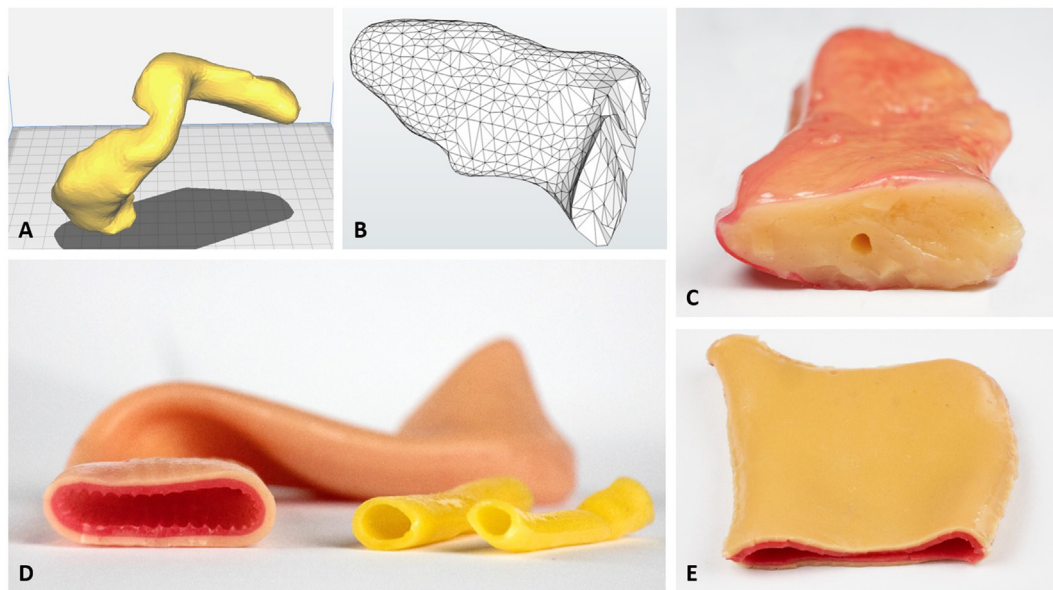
Silicone organ models. A: Pancreas 3D reconstruction of CT imaging. B: Final 3D pancreas model after virtual pancreatic head resection. C: Soft pancreas model with 3 mm duct. D: Small bowel with 2.5 mm wall thickness and soft bile ducts with 6 mm and 4 mm inner diameter. E: Stomach with 5 mm wall thickness
